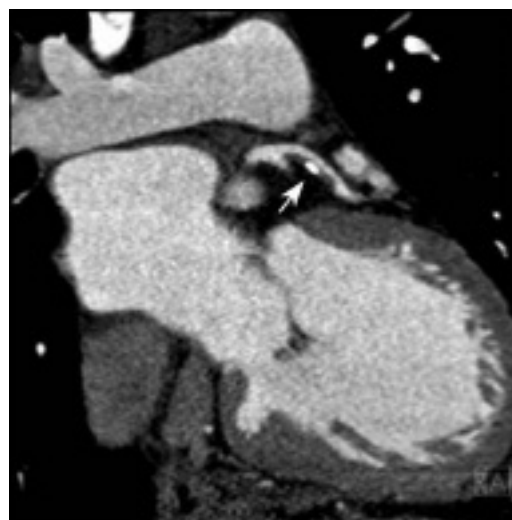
In this multidetector computed tomography scan, the arrow indicates mixed (calcified and noncalcified) plaque.
